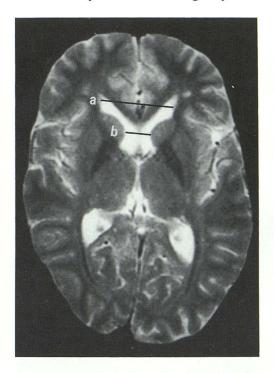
Measurements of the width of the lateral ventricles were made at two points, shown on these T2-weighted images. Line (a) is through the frontal horns at the widest point and line (b) is through the frontal horns at the level of the caudate-putamen impingement. Calvarial width and brain width measurements were made at each level. Measurements were also made of the width of the third ventricle at the trigonum habenulae.
